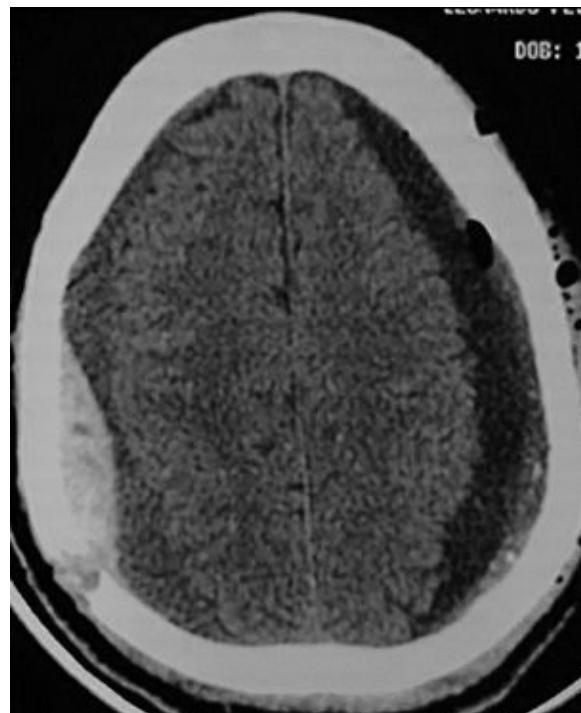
Non-contrast-enhanced cranial CT control 12 hours after surgery, demonstrating post-surgical status and presence of right parietal epidural hematoma.
